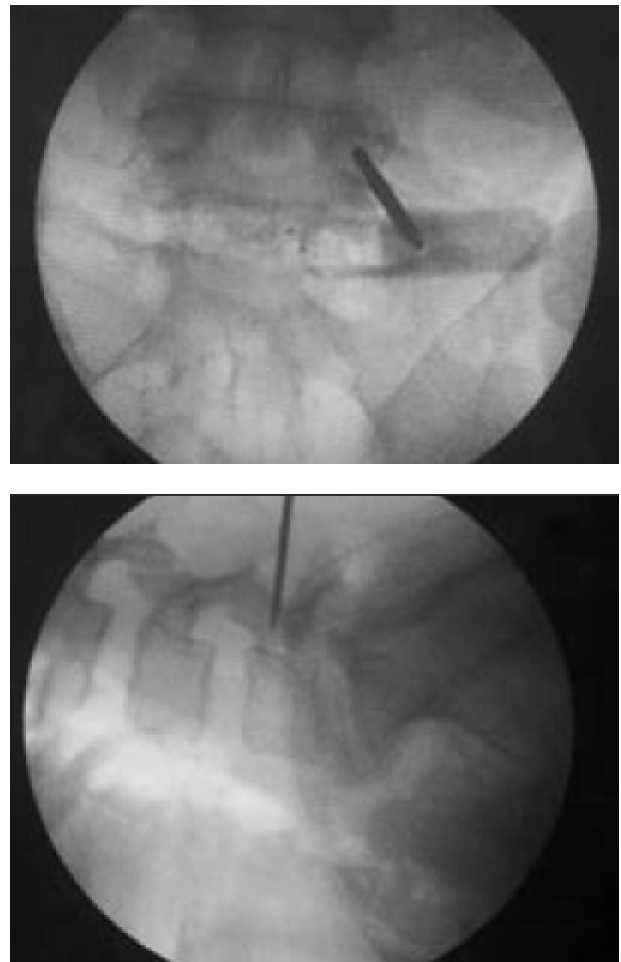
Intra-operative marking for “through the skin” entry point into the pedicle under X-ray guidance.
